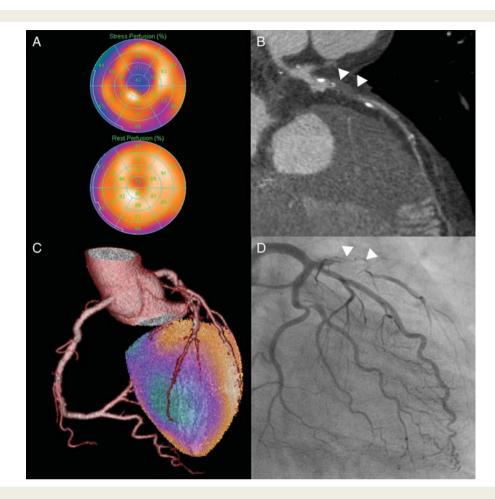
Figure I Example of a 47-year-old patient with typical angina. His stress and rest myocardial perfusion single-photon emission computed tomography (A) show a reversible anteroapical perfusion defect. On computed tomography angiography, a complete occlusion of the proximal left anterior descending artery can be observed (arrowheads in B) with distal vessel opacification suggesting collateralization. The hybrid volume-rendered single-photon emission computed tomography/computed tomography images (C) demonstrate that the anteroapical ischaemic territory is supplied by the occluded left anterior descending artery. The invasive angiogram confirms the total occlusion of the proximal left anterior descending artery (D, arrowheads).
